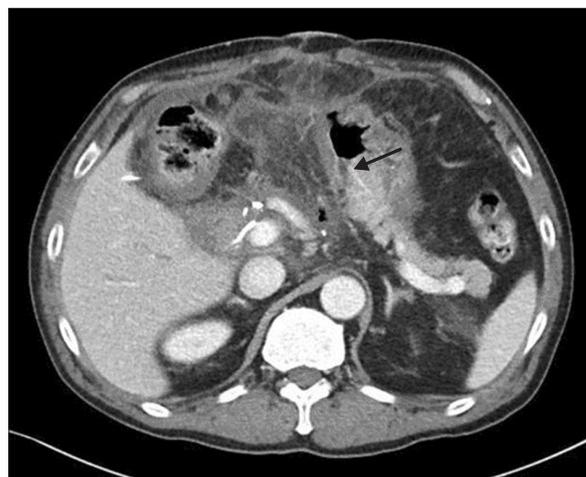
Axial computed tomography image taken after the pancreaticogastrostomy. The pancreatic stump with internal stent (arrow) is visibly protruding into the stomach lumen after conversion to pancreaticogastrostomy.
